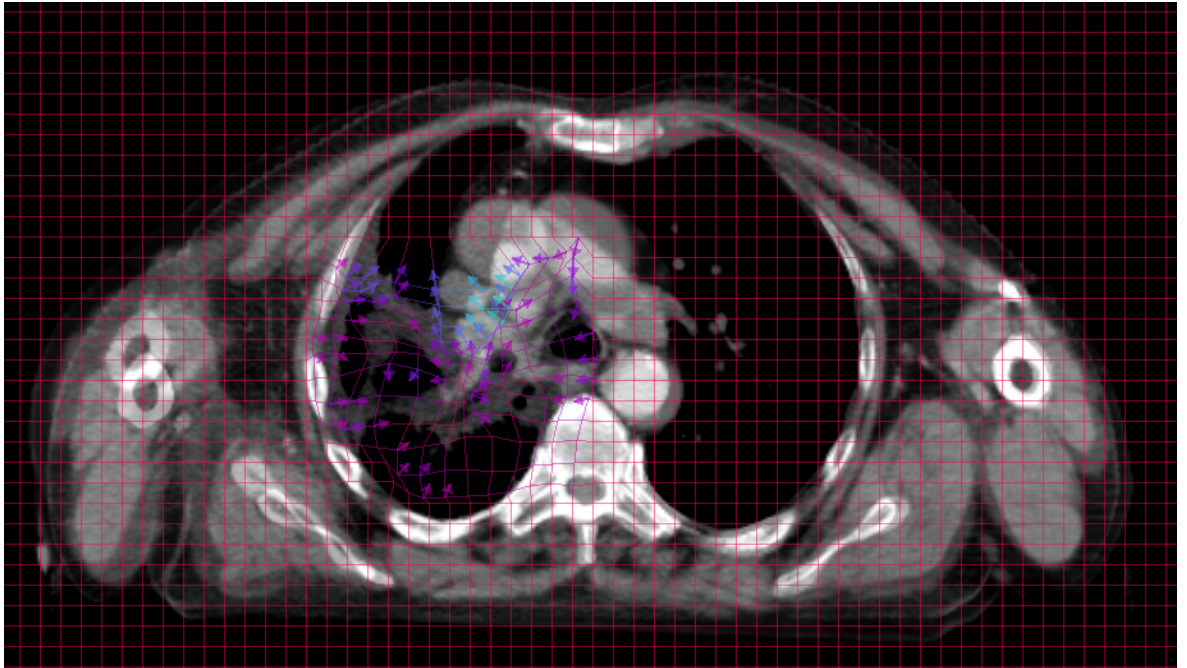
Direction vectors with a limited region of interest Region of interest was set to 2cm superior and inferior to the planning target volume. Purple lines demonstrate the direction the initial planning CT scan was warped to align with the re-irradiation planning CT.
